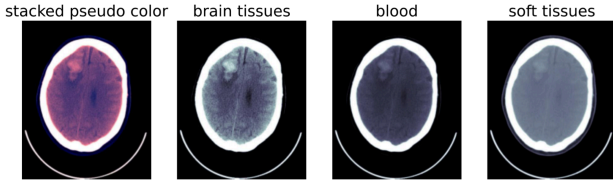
The conversion from CT slice to the 3-channel image. The slice is intraparenchymal hemorrhage positive and one can easily see the blood in the brain tissue and blood windows.
